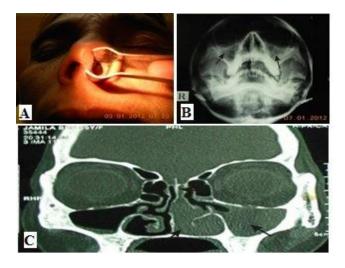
(A and B) Preoperative photograph of adenocarcinoma of LT nasal cavity showing mass in Lt nasal cavity X ray waters view showing haziness in B/L maxillary sinus. (C) CT scan PNS coronal section showing the homogenous soft tissue opacification seen in Lt maxillary Lt ethmoid sinus and Lt nasal cavity.
